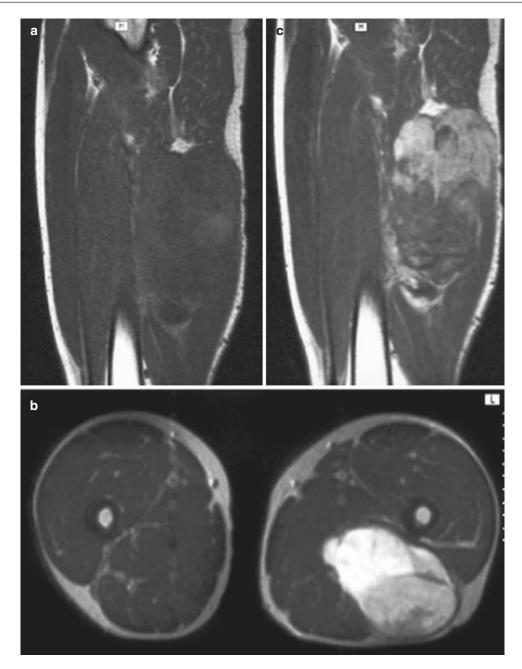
Extraskeletal Ewing's sarcoma of the left thigh in a 29-year-old man. (a) Sagittal spin-echo T1-weighted MR image. (b) Axial spin-echo T2-weighted MR image after gadolinium contrast injection. A large polylobular mass at the posterior aspect of the femur is seen. On the T1-weighted image, the lesion appears inhomogeneous, and signal intensity is nearly equal to that of surrounding muscle. Ill-defined, slightly hyperintense area posteriorly in the lesion suggests intratumoral hemorrhage (a). On the T2-weighted image, the polylobular shape of the lesion is
